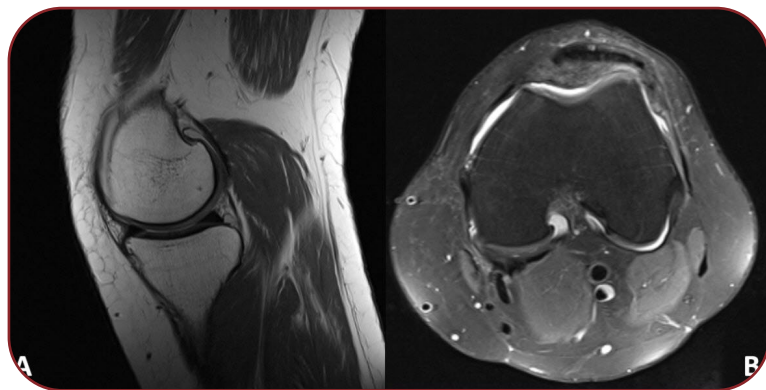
Postoperative magnetic resonance imaging (MRI) at one-year follow-up showing no signs of tumor recurrence: (A) sagittal view; (B) transverse view
